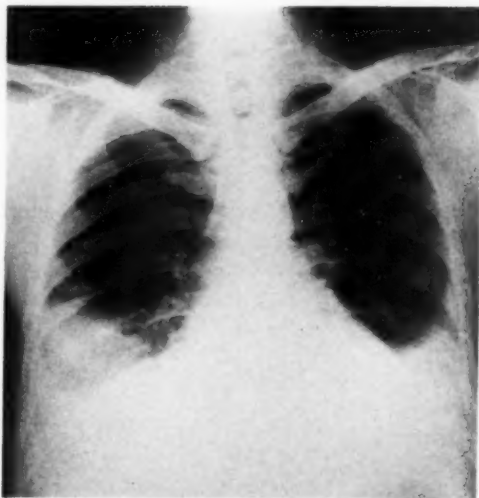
Case VI: Amyloidosis of heart. Roentgenogram of the chest showing pulmonary congestion, cardiac enlargement, and bilateral pleural fluid.
